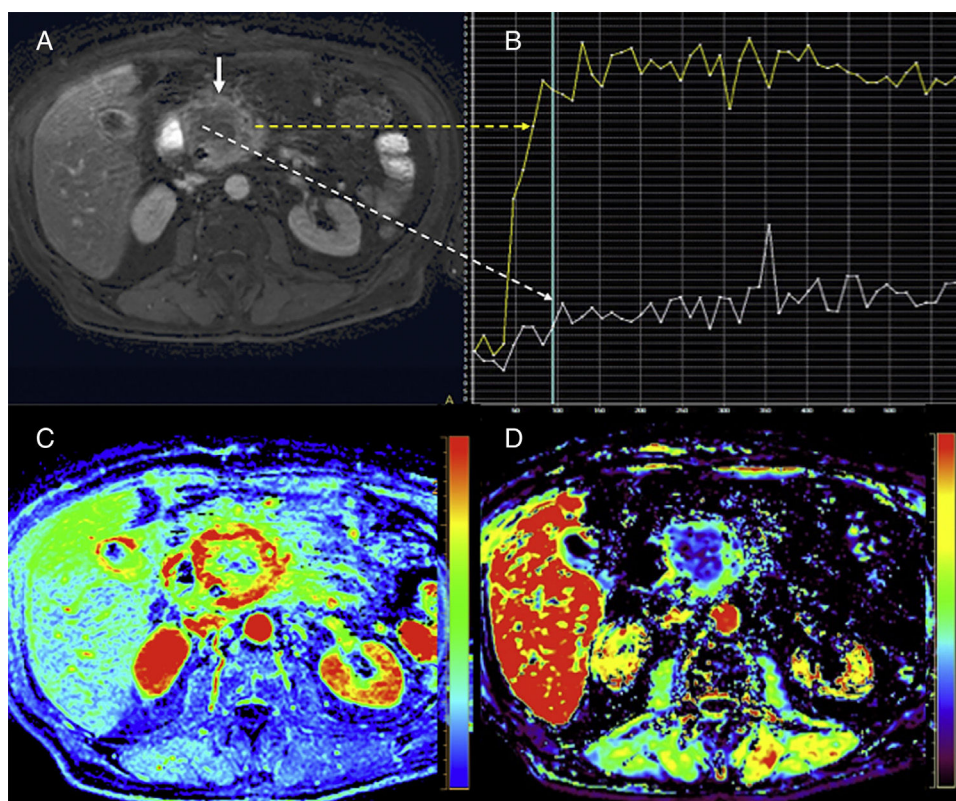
Pancreatic magnetic resonance perfusion imaging study of a patient with head gland pancreatic adenocarcinoma. The dynamic MRI study with contrast (A) conducted shows one large mass with poorly-established edges and extensive areas of central necrosis (white straight solid arrow). The uptake curves (B) show clear differences in the central portion with little enhancement (white curve and dotted arrow) while the more feasible periphery shows type II curve pattern (yellow curve and dotted arrow) with fast enhancement and plateau after the enhancement peak. Also, perfusion allows us to evaluate tissues based on semiquantitative parameters that analyze the characteristics of the enhancement curves such as the area under the curve (AUC) (image C) or quantitative parameters such as the efflux rate constant (K_{ep}) (image D) based on mathematical models that are more difficult to obtain but also much more biologically significant.
